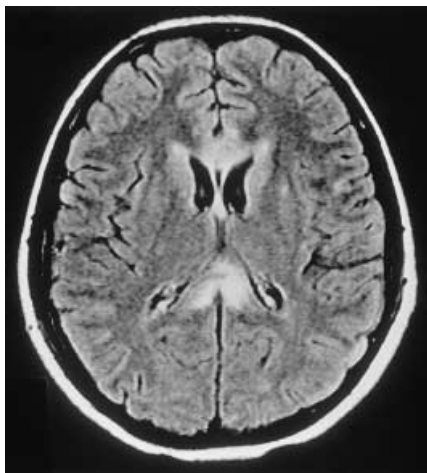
Traumatic lesion along the corpus callosum in a 48-year-old patient had an accident 2 years before the MRI. Diffuse axonal injury caused a large, asymmetrical areals gliosis involving the entire corpus callosum
